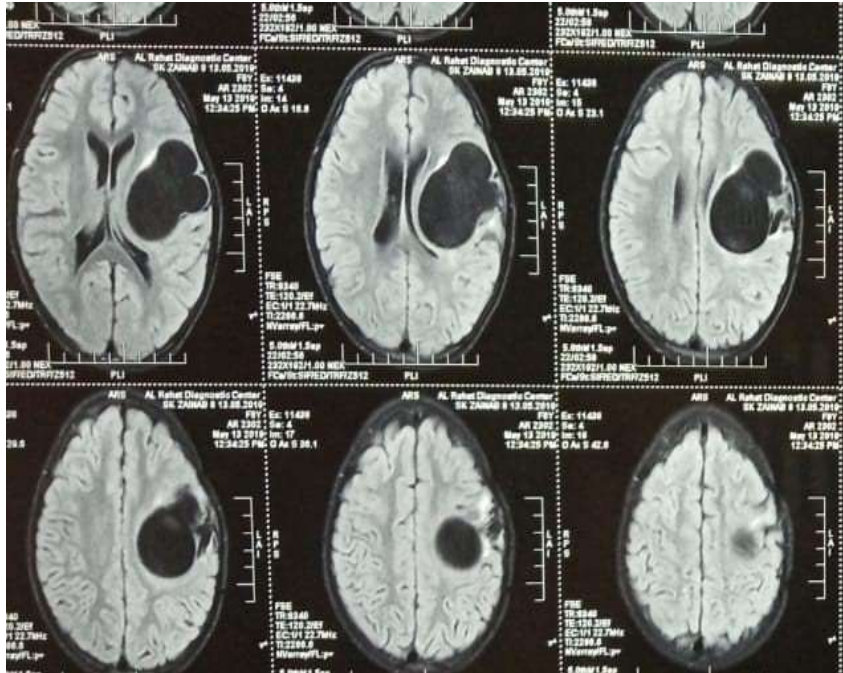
MRI brain revealing heterogenous enhancing three cysts within left temporal lobe suggestive of hydatid cyst.
